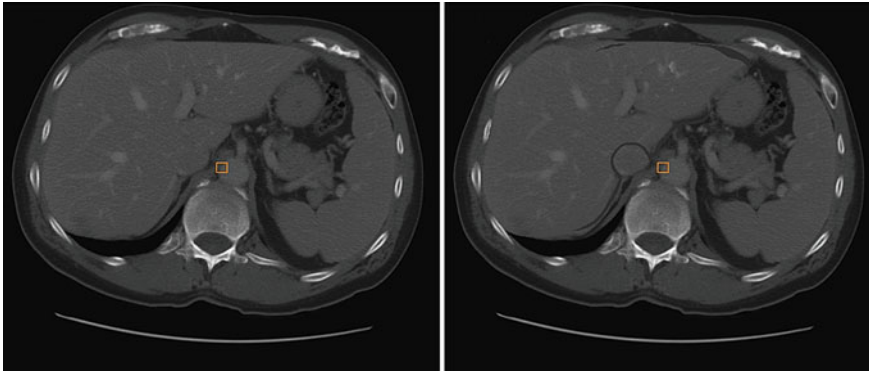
An axial slice of the undeformed CT volume (*left*) and the corresponding deformed volume (*right*)
